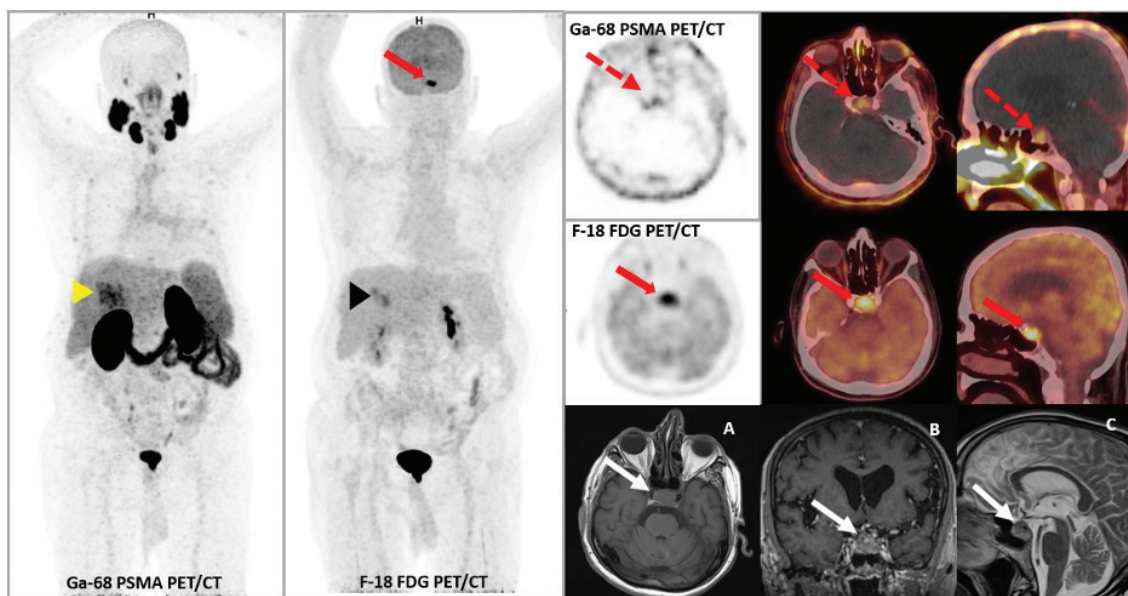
A 76-year-old man underwent radical prostatectomy for prostate adenocarcinoma 4 years ago. The patient received chemoradiotherapy due to castration resistance and was referred to ^{68}Ga prostate-specific membrane antigen (PSMA) positron emission tomography/computed tomography (PET/CT) for restaging. He also had a history of lung cancer and stereotactic radiotherapy to a lesion in left lung. A consecutive ^{18}F -fluorodeoxyglucose (FDG) PET/CT was performed for evaluation of lung cancer remission. Metastatic lesions in liver are seen in both PET/CT images (maximum intensity projection images, arrowheads). Intense ^{18}F -FDG uptake was observed in pituitary gland in axial and sagittal slices of ^{18}F -FDG PET/CT [maximum standardized uptake value (SUV_{max}): 13.94] (red arrows). Axial and sagittal PET and fusion images showed mild ^{68}Ga PSMA uptake (SUV_{max} : 1.88) in the pituitary gland (dashed arrows). Magnetic resonance imaging (MRI) examination of pituitary gland-verified macroadenoma filling and expanding the sella in T1 weighted sequences axial slice (A), contrast-enhanced coronal slice (B), and T2 weighted sequences sagittal slice (C). Pituitary adenomas are detected incidentally in oncological ^{18}F -FDG PET/CT and the incidence was found as 0.073% in a multi-center study (1,2). The SUV_{max} value was determined as 4.1 in another study conducted with ^{18}F -FDG PET/CT to discriminate physiological and pathological involvement (3). Pituitary lesions can be detected with high accuracy in contrast-enhanced MRI (4). PSMA PET/CT plays a significant role in diagnosis and treatment response assessment in prostate cancer patients (5). Various benign lesions with PSMA uptake have been reported (6,7,8). We showed the mild uptake on ^{68}Ga PSMA PET/CT in a pituitary adenoma for the first time to our knowledge.
